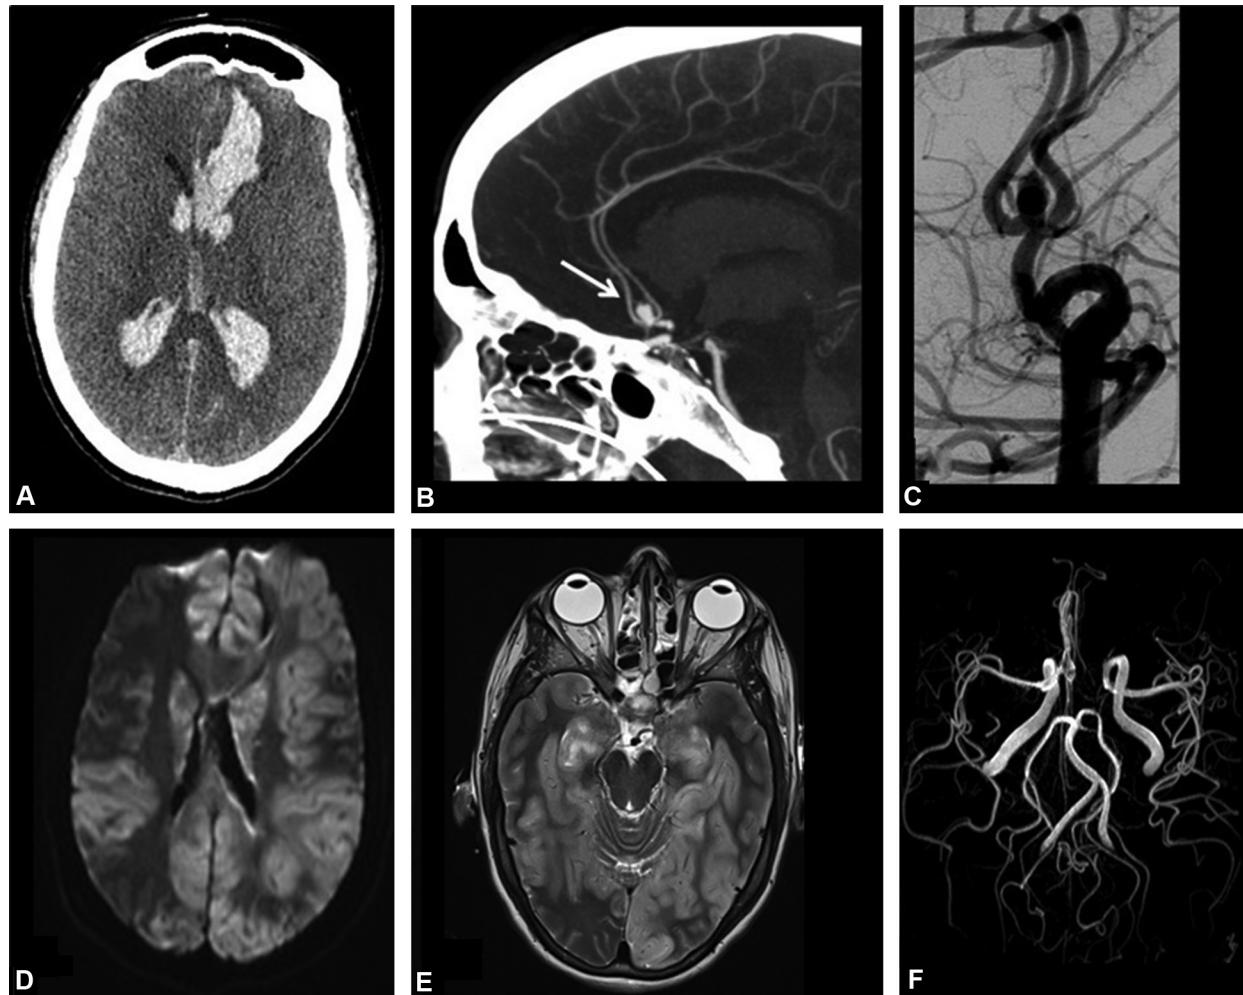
Thirty-six year old female patient with sudden-onset headaches, vomiting and abnormal consciousness level. Glasgow score 4. Bilateral meiosis. Unenhanced cerebral CT showing a hyperdensity in the cortical sulci with a left frontal intraparenchymal hematoma and ventricular flooding suggestive of a Fisher grade 4 subarachnoid hemorrhage (A) due to rupture of an anterior communicating artery aneurysm seen on the sagittal MIP reconstructions after enhancement (B, arrow) and cerebral arteriography (C). Abnormal transcranial Doppler ultrasound on D3. Cerebral MRI on D3 showing huge hyperintense b1000 cortico-subcortical lesions (D), and on T2 weighted imaging (E) with no appearances of vasospasm of the intracranial vessels on time of flight imaging (F) suggestive of diffuse cortical ischemic lesions. The patient died on D6.
